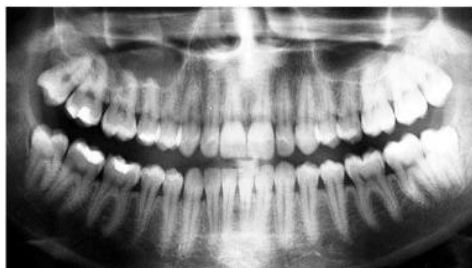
Contrast enhanced x-ray image
